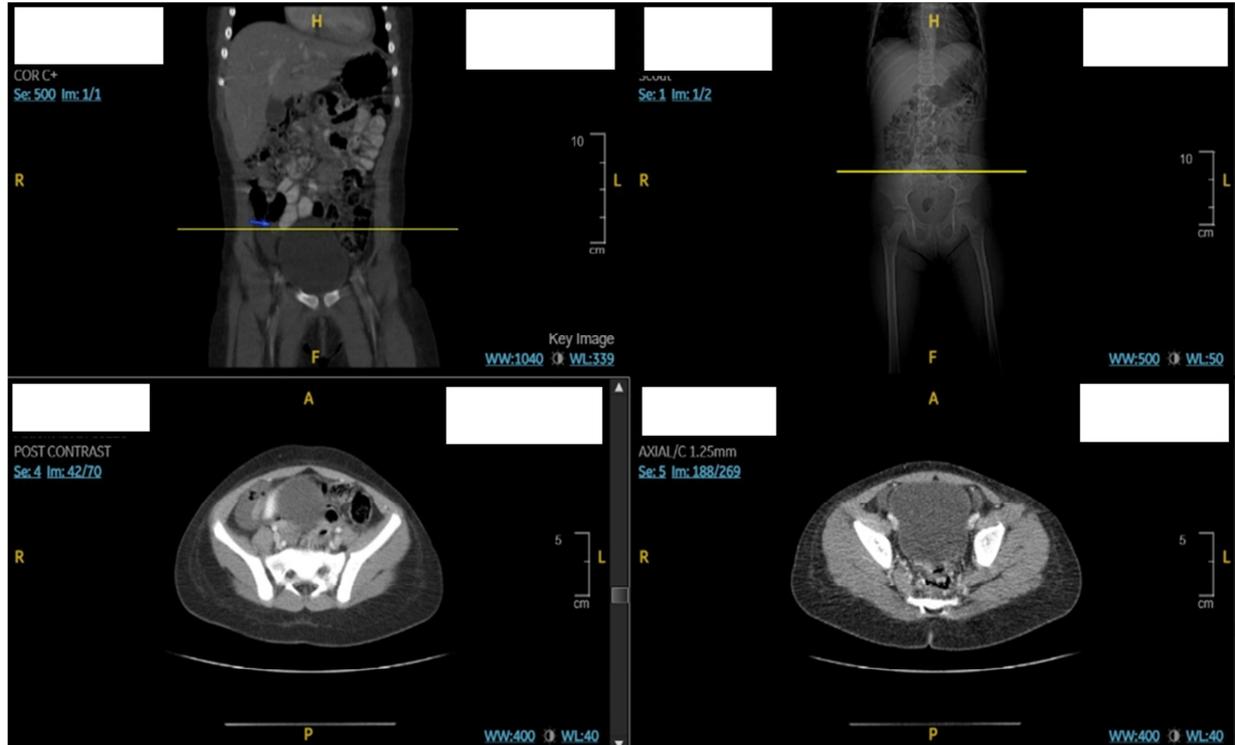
Enhanced CT of the abdomen: acute perforated appendicitis (appendix thick wall enhancement surrounded with free fluid collection).
